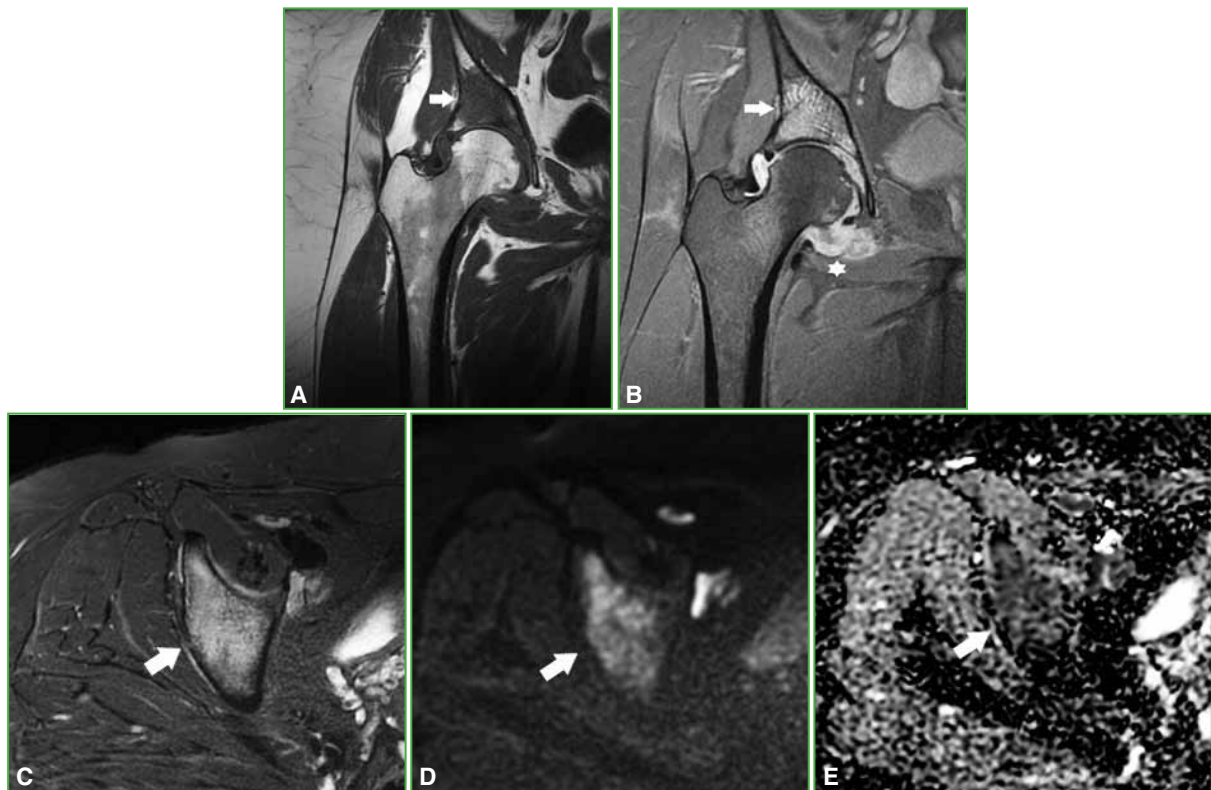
Magnetic resonance imaging of the right hip. A. Coronal section in T1-weighted sequence. A hypointense lesion is visualized in the roof of the acetabulum (arrow). B. Coronal section in STIR sequence. The lesion becomes hyperintense (arrow) and a heterogeneous hip effusion is observed (asterisk). C. Axial section in STIR sequence. Hyperintense lesion (arrow). D and E. Axial section in diffusion sequence (D) with the corresponding apparent diffusion coefficient map (E), showing intermediate cellularity.
